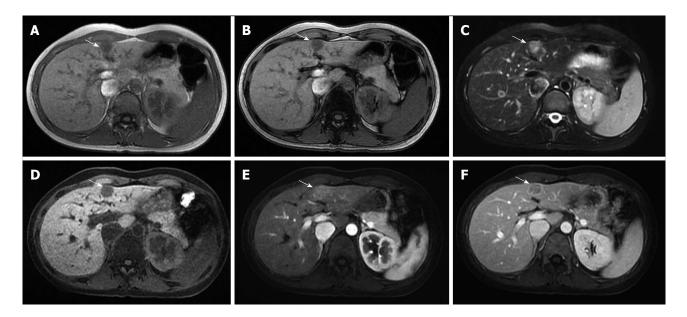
Liver magnetic resonance images demonstrated a small lymphoepithelioma-like cholangiocarcinoma at the medial segment of the liver (arrow). A: In-phase T1-weighted image; B: Out of phase T1-weighted image; C: Axial T2-weighted image with fat suppression; D: Pre-contrast; E: Arterial T1-weighted image; F: Portal venous phase T1-weighted image with fat suppression.
